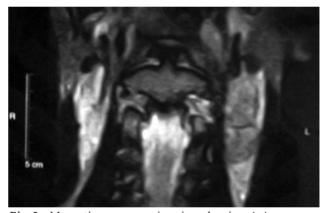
Magnetic resonance imaging showing 4x4 cm mass on the left side of the neck which was settled on upper jugular region the front of sternocleidomastoid muscle.
